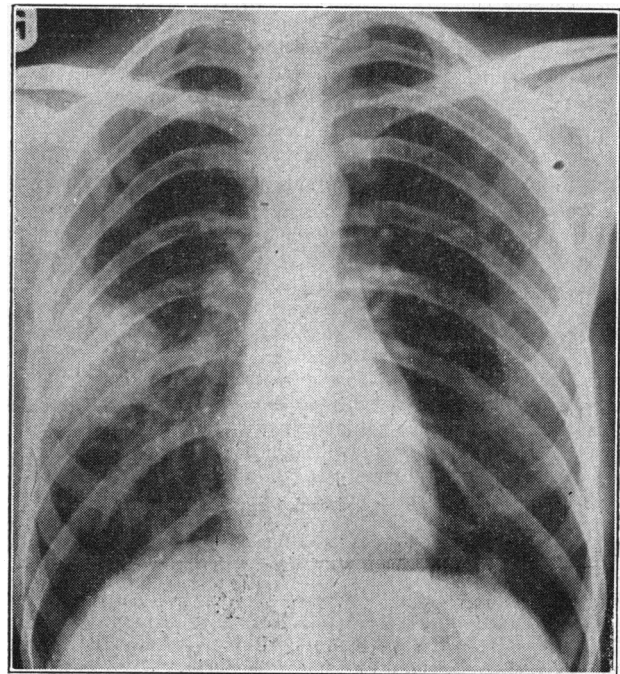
Chest x-ray film four weeks before death, showing marked increase in size of pulmonary metastases.
